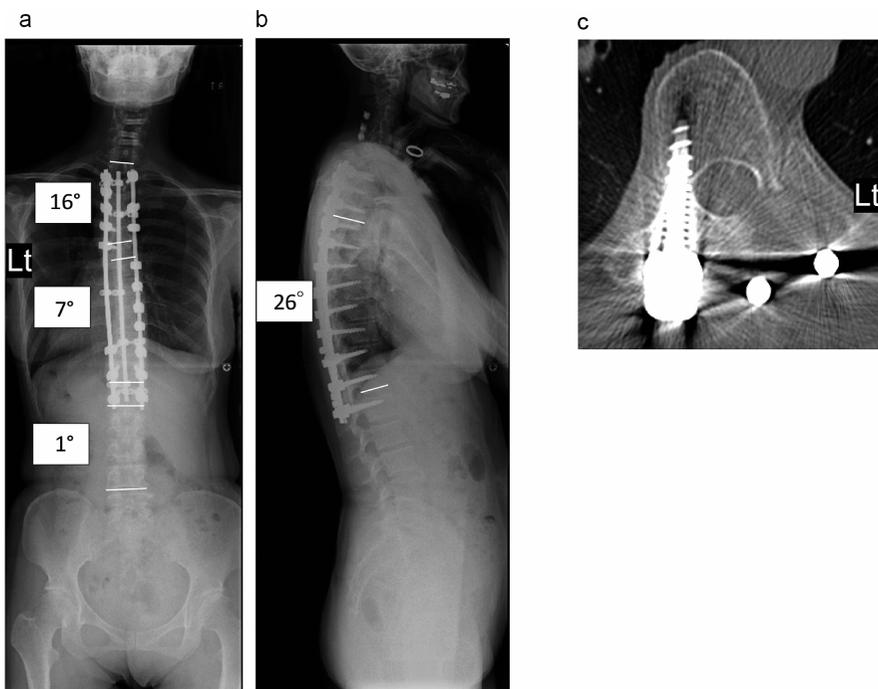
Postoperative whole-spine X-ray and computed tomography (CT) images
